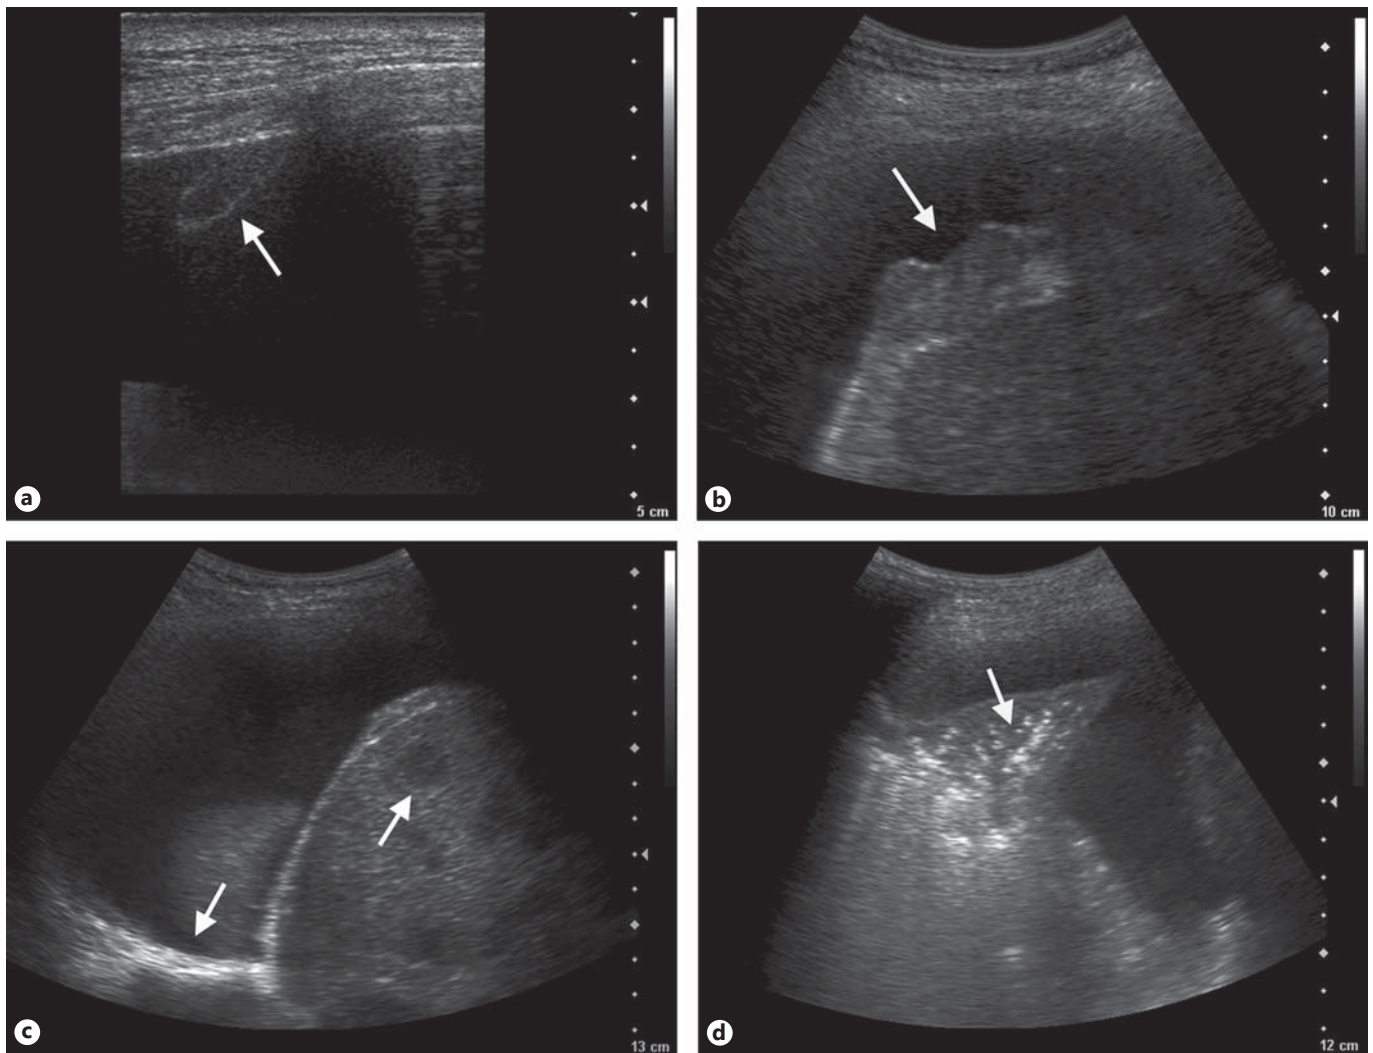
Transthoracic US features in MPE and benign pleural effusions. a Parietal pleural deposit (arrow) surrounded by an anechoic pleural effusion in a 67-year-old man with metastatic squamous cell lung cancer. b Nodular thickening of the diaphragmatic pleura (arrow) in a 60-year-old man with renal cell carcinoma pleural metastasis. c Right-sided pleural effusion with increased visceral
